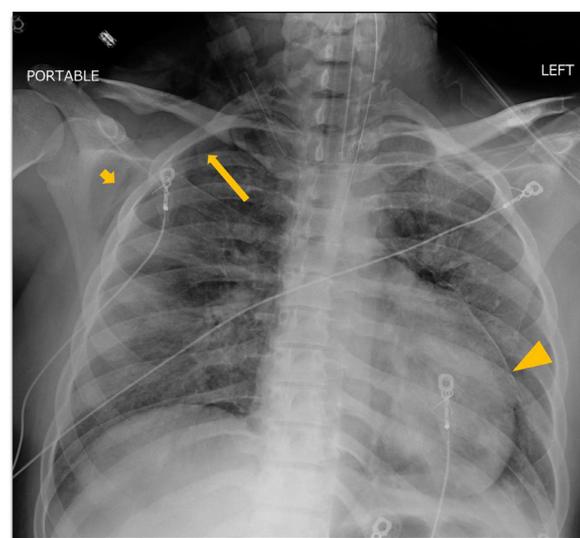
Frontal chest radiograph demonstrates subcutaneous emphysema in the right lower neck and chest wall (short arrow), a small right apical pneumothorax (arrow), and pneumomediastinum (triangle) in this intubated patient with moderate severity of bilateral pulmonary opacities. Also of note, the enteric tube is malpositioned.
